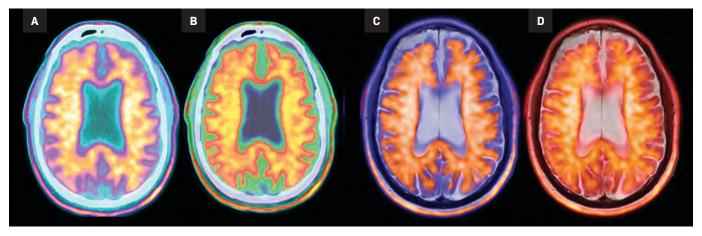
Positive FDG PET study demonstrating statistically significant cortical hypometabolism in the bilateral mesiotemporal lobes. (A,B) FDG PET-CT fusion images; (C,D) FDG PET-MR fusion images (with axial T2 used for MR fusion).
